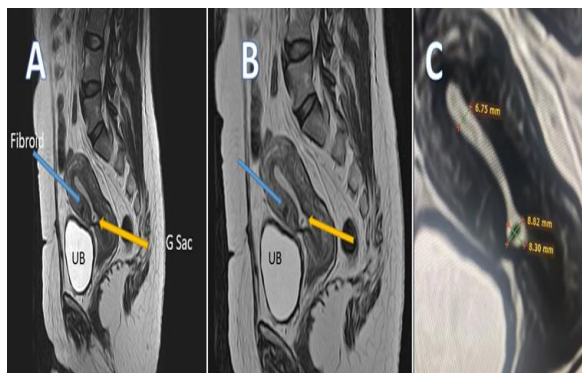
MRI images showing the presence of a well-defined cystic lesion in the lower uterine segment at the site of the previous scar of 8.7 X 8.0 mm (demarcated by an orange arrow) not extending into the urinary bladder, suggesting a C-scar ectopic pregnancy (A and B). There is a small anterior fibroid demarcated by a blue arrow. The endometrial thickness is measured 6.75 mm, and the gestational sac (C).
